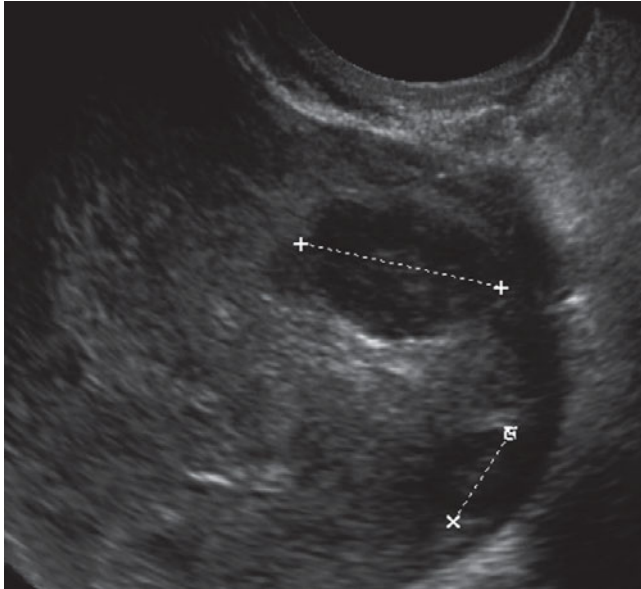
Ultrasonography. Adenomyosis, focal form. Two-dimensional sonogram in the sagittal plane shows two hypochoic nodules (*crosses*) and absence of pseudocapsule
